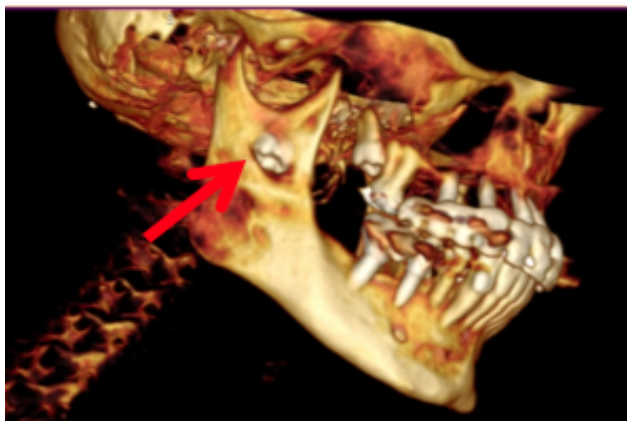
3D volume reconstruction of CT mandible and Neck, Ectopic LR8 (denoted by Arrow).
